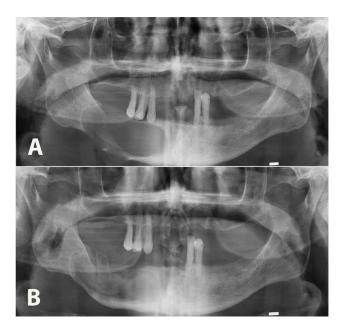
Definitive surgery is performed after considerable reduction in lesion size and/or distancing from anatomical structures is achieved. (A) Pre-decompression orthopantomogram (OPG) of a cystic lesion extending to the inferior border of the mandible. (B) OPG following 14-month of decompression. A significant reduction in lesion size is observed.
